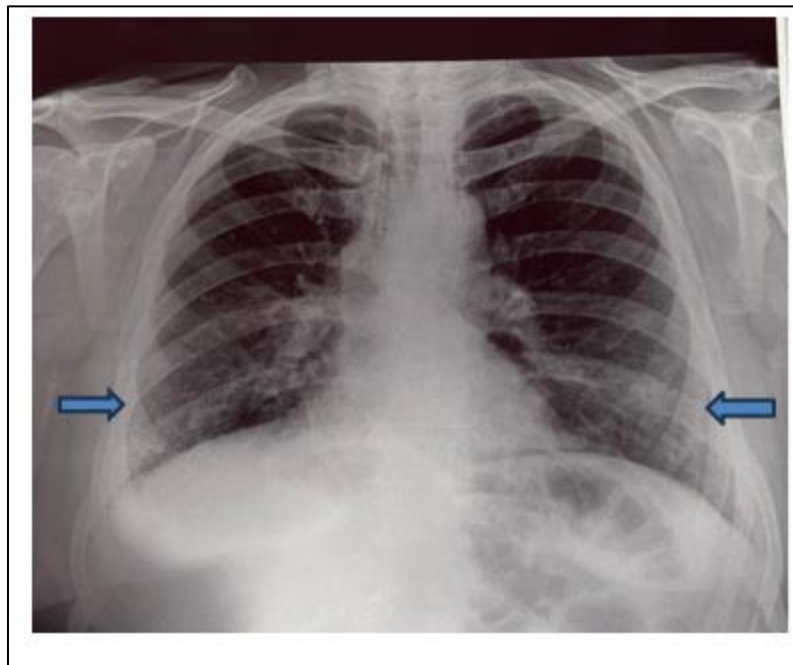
AP Chest X-ray showing diffuse bilateral reticulomicronodular opacities
